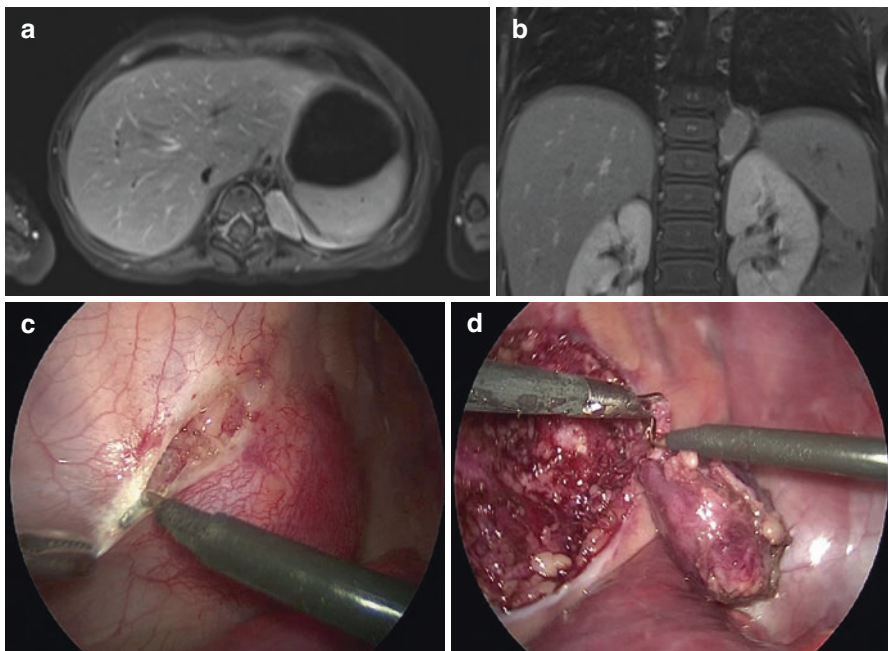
Paravertebral left-sided thoracic neuroblastoma in a child with Opsomyoclonus Syndrome. (a, b) Preoperative MRI Scan. (c)
